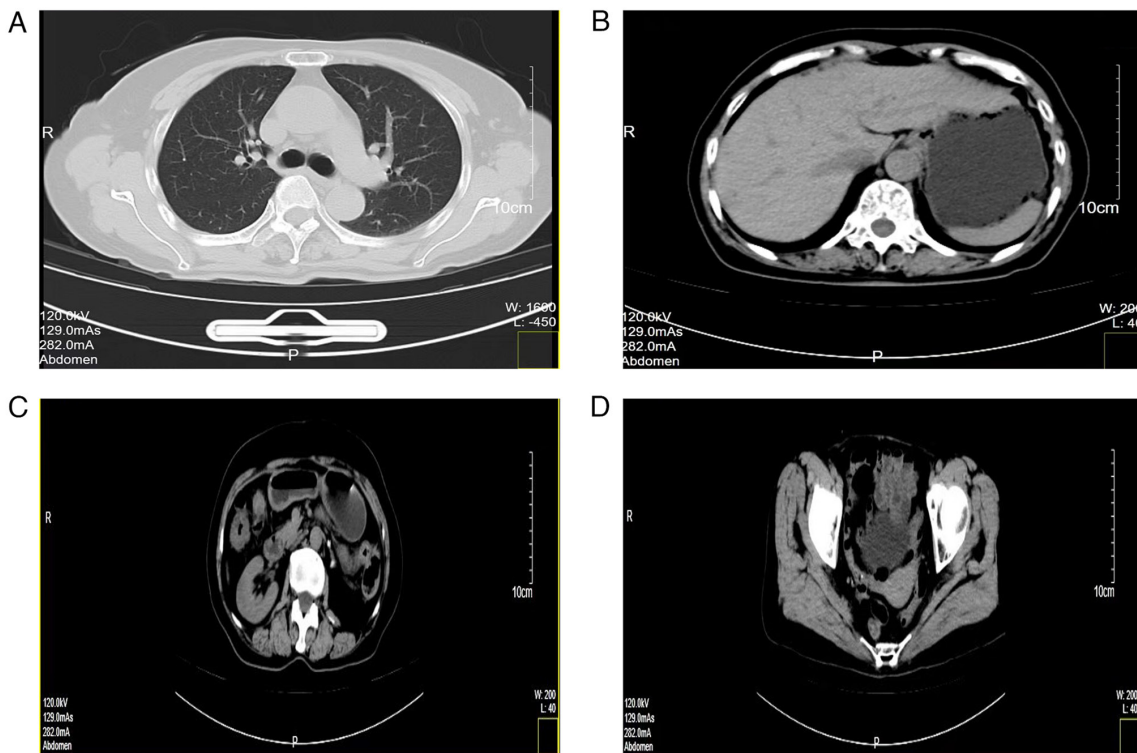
Enhanced computed tomography of the chest, abdomen and pelvic regions 15 months post-surgery indicated no mass lesions. Representative images of the (A) lungs and mediastinum, (B) liver, gallbladder and stomach, (C) intestinal tract and right kidney and (D) uterus, bilateral adnexa and bladder.
